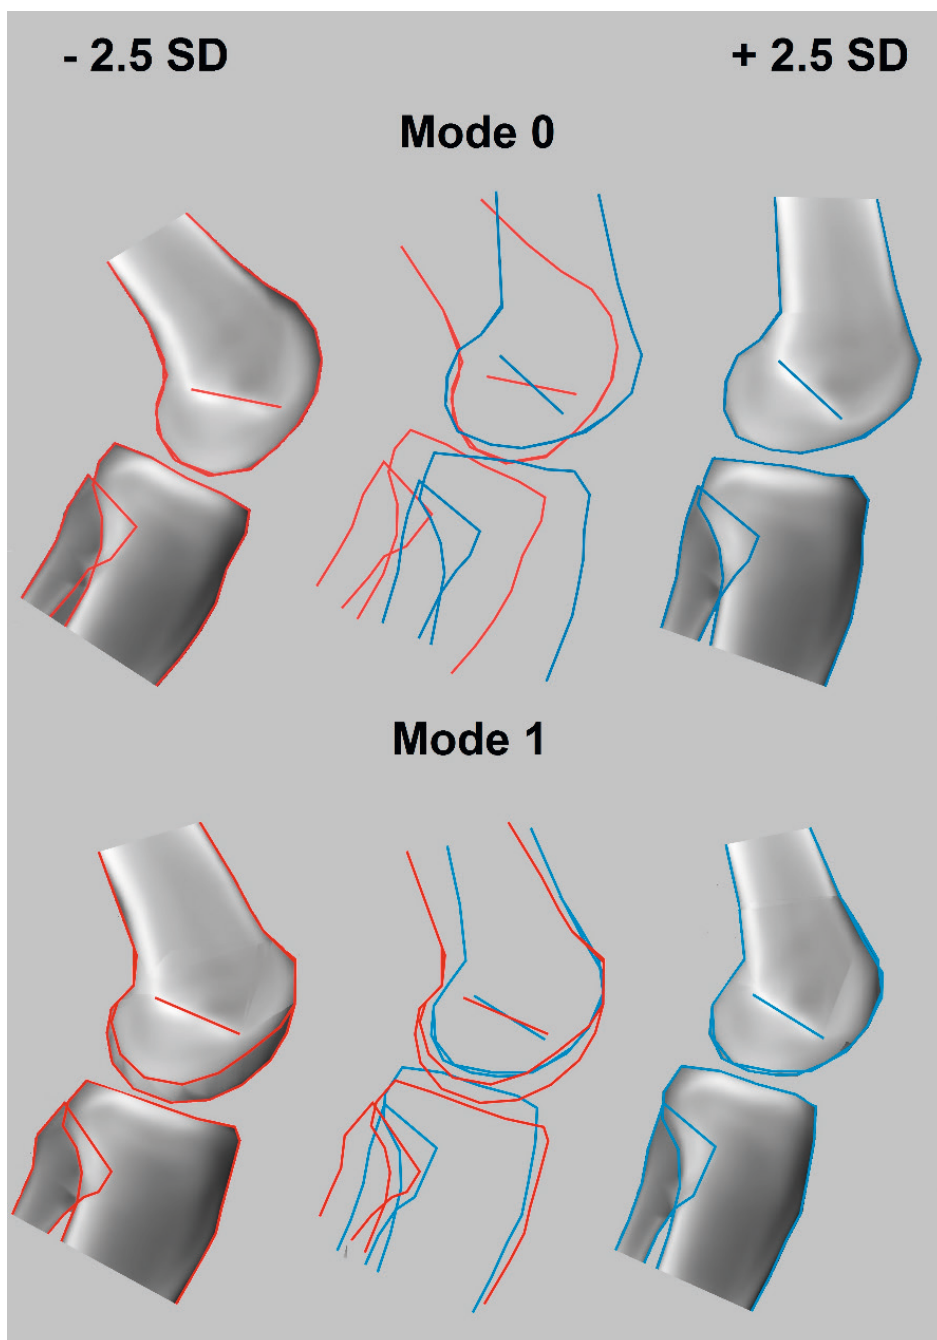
Graphic outcomes of statistical shape modelling: variation in flexion of the knee when the radiograph is taken. On the left and right side are standard deviation scores of -2.5 and 2.5, respectively, and in the middle is the overlay of both sides.
